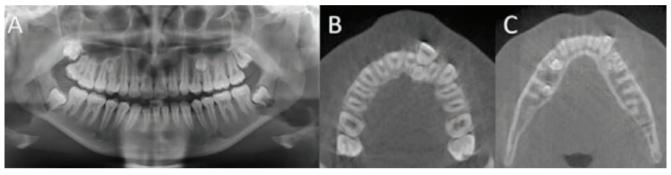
Supernumerary teeth observed in different patients: on panoramic radiograph in the upper premolars regions (A), the palatal position (B) and the lingual position in relation to the teeth of the normal series seen in axial sections of cone beam computed tomography (C).
